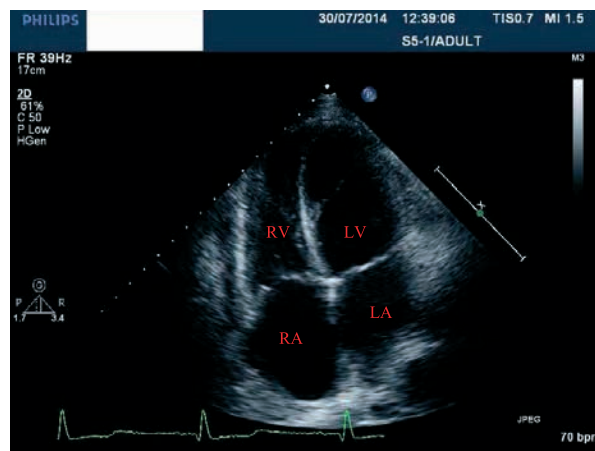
Echocardiographic image showing patient's apical four chamber view. Recording made on July 30th 2014. Normal cardiac chamber size is seen.
